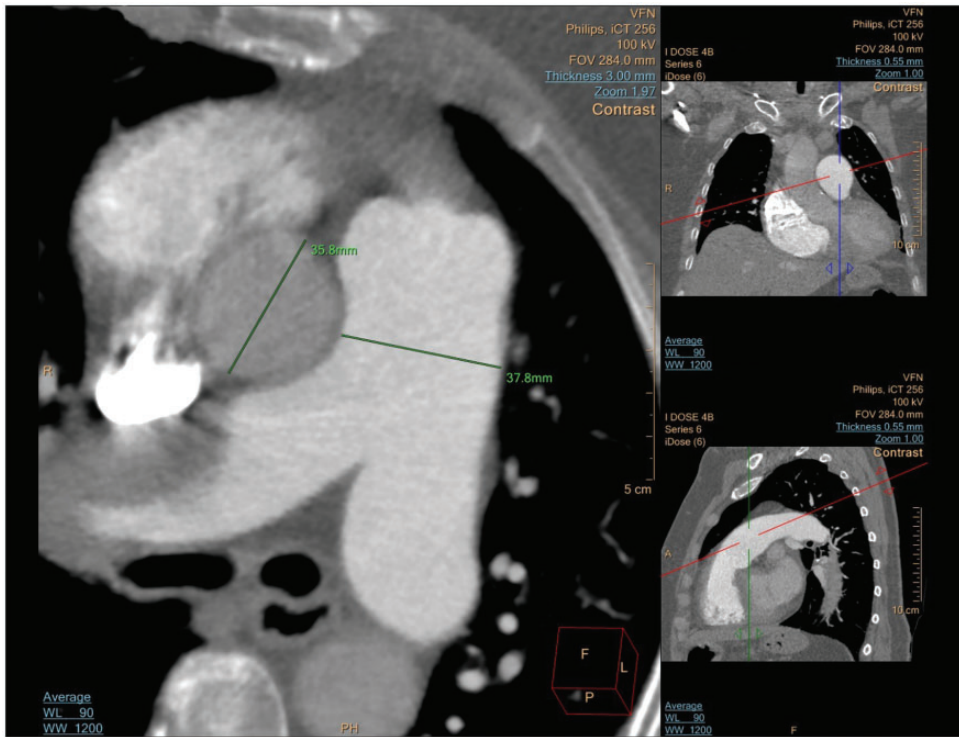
Computed tomography images showing measurement of the diameters of the main pulmonary artery and ascending aorta.
